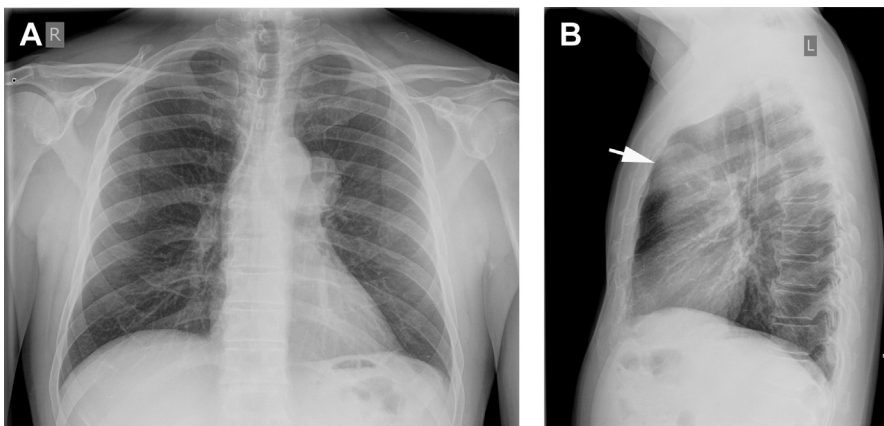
Anterior mediastinal mass. (A) PA chest radiograph shows a left mediastinal mass that demonstrates the hilum overlay sign. (B) Lateral chest radiograph allows localization of the mass to the anterior mediastinum (arrow). Thymoma subsequently was diagnosed.
